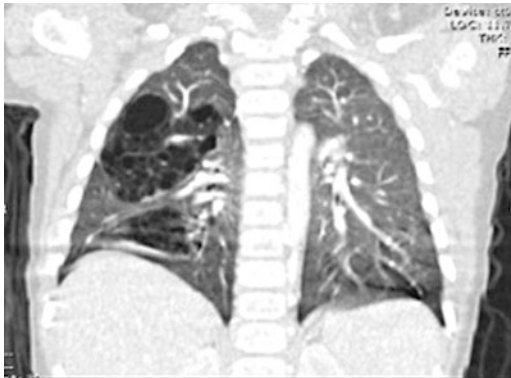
CT scan showing multilobar CPAM involving the entire right lung.
